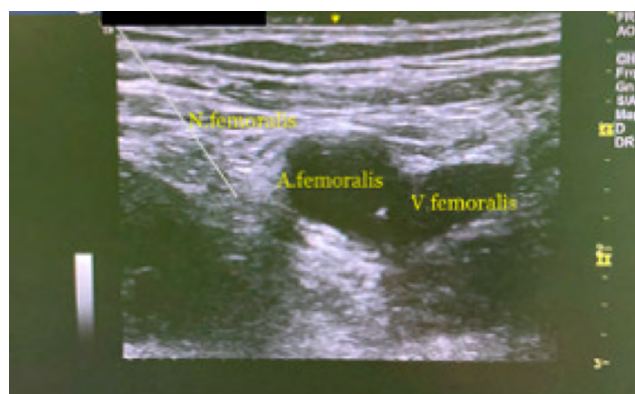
Ultrasound image of femoral nerve and surrounding structures.
